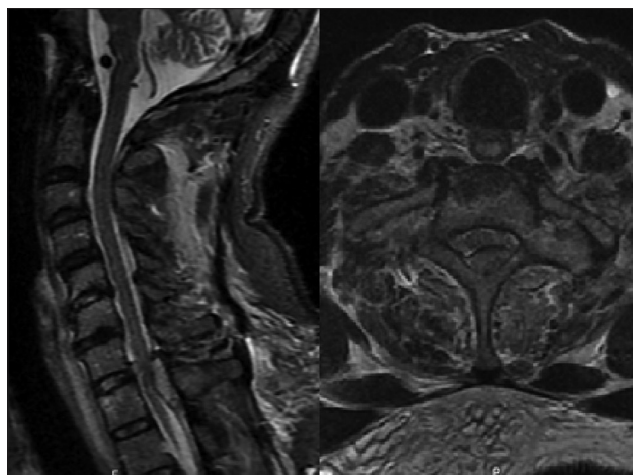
Preoperative MRI cervical spine sagittal STIR (left) and axial T2 (right) showing dorsal epidural hematoma causing cord compression at C7–T1
